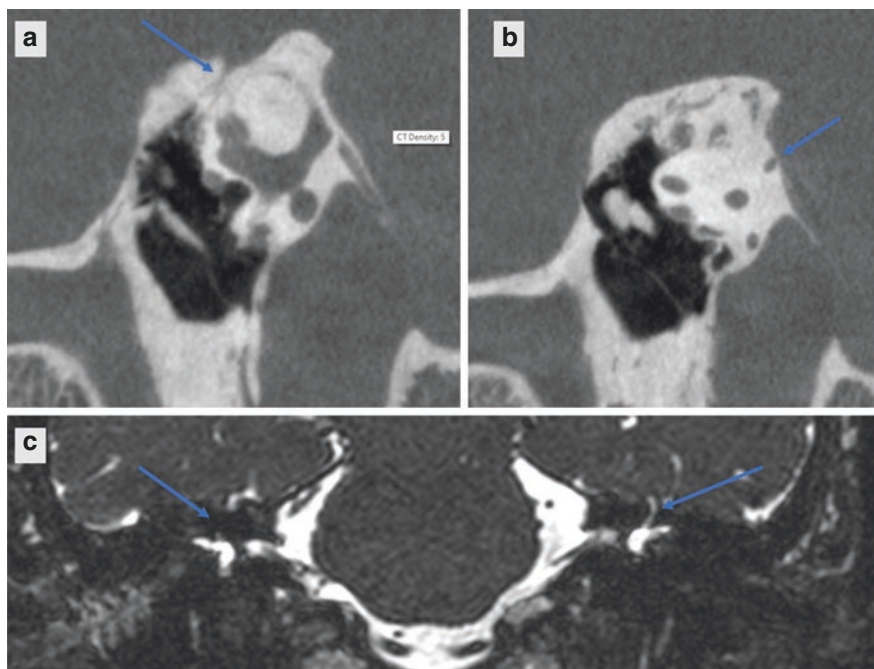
Three prior surgeries—round window reinforcement, transmastoid SSCD occlusion and Middle Fossa SSCD occlusion with persistent symptoms. (a) Well occluded and resurfaced SSCD (arrow) with ossification of SSC lumen. (b) PSCD (arrow) not yet repaired. (c) MRI demonstrating absence of the SSC signal and confirming occlusion. Right arrow points to absent SSC signal and left arrow points to normal SSC signal. Surgical repair of the PSCD with calvarial bone resolved the patient's symptoms
